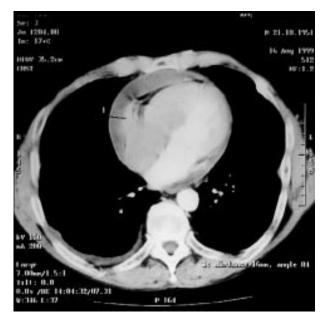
Case 1: chest computed tomographic scan showing the pericardial effusion due to RV.
